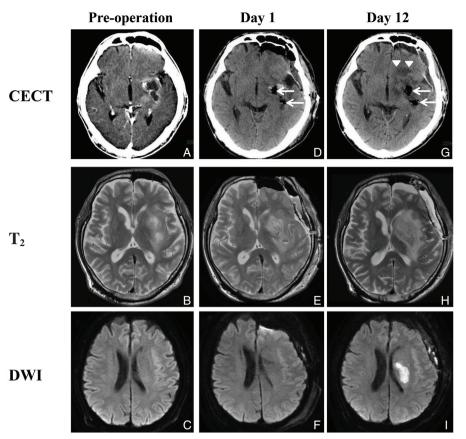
CT and MRI findings pre-operatively (A–C), at day 1 after the operation (D–F), and at day 12 (G-I). A: CT with contrast medium showing a ring-enhanced mass with irregular margins (diameter, 40 mm) in the temporal lobe and insula. B: T2-weighted image showing a hyperintense lesion. C, F: Diffusion-weighted MRI (DWI) showing no hyperintense lesions. D: CT showing entrapped air in the resected cavity (arrows). E: T<sub>2</sub>-weighted image showing mild perifocal edema and subdural air. G: CT showing enlargement of entrapped air in the resected cavity (arrows) with perifocal edema (arrowheads). H: T2-weighted images showing severe edema. I: DWI showing a hyperintense lesion in the left corona radiata, suggesting acute cerebral infarction. CECT: contrast-enhanced computed tomography, CT: computed tomography, MRI: magnetic resonance imaging.
